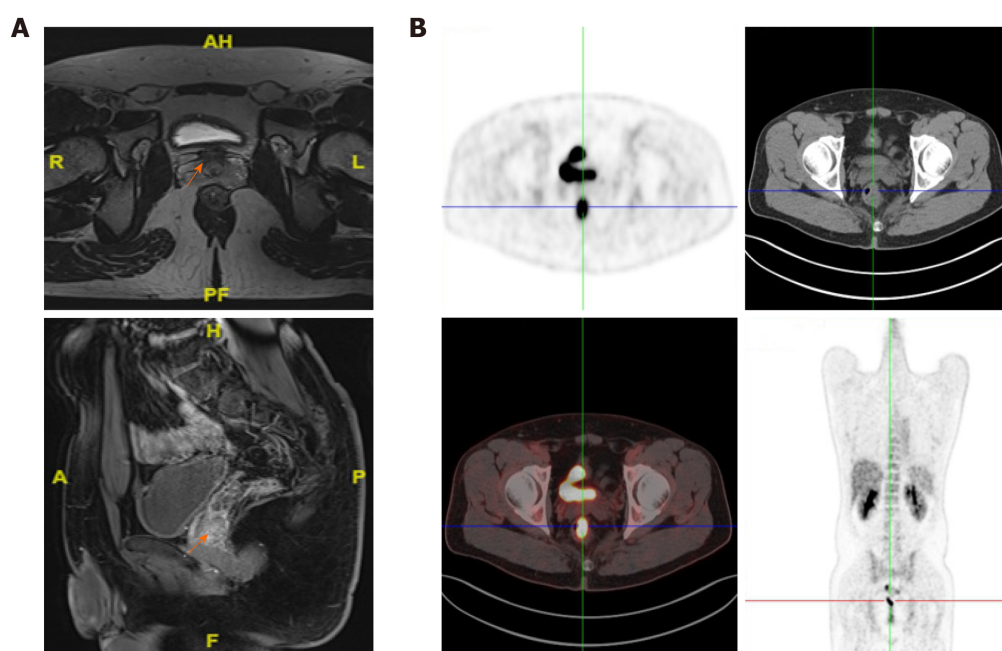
Axial computed tomography images reveal a rectal mass. A: Axial maximum intensive projection at the same imaging level, and coronal images showed a 40 mm solitary nodule approximately 58 mm away above the anus in the rectum; B: Axial images of positron emission topography-computed tomography at the same imaging level, and rectal image of positron emission topography-computed tomography maximum intensive projection showed a thickened medial rectum wall with homogeneous uptake of 18F-fluorodeoxy-glucose, and the maximum standardized uptake value was 14.6.
